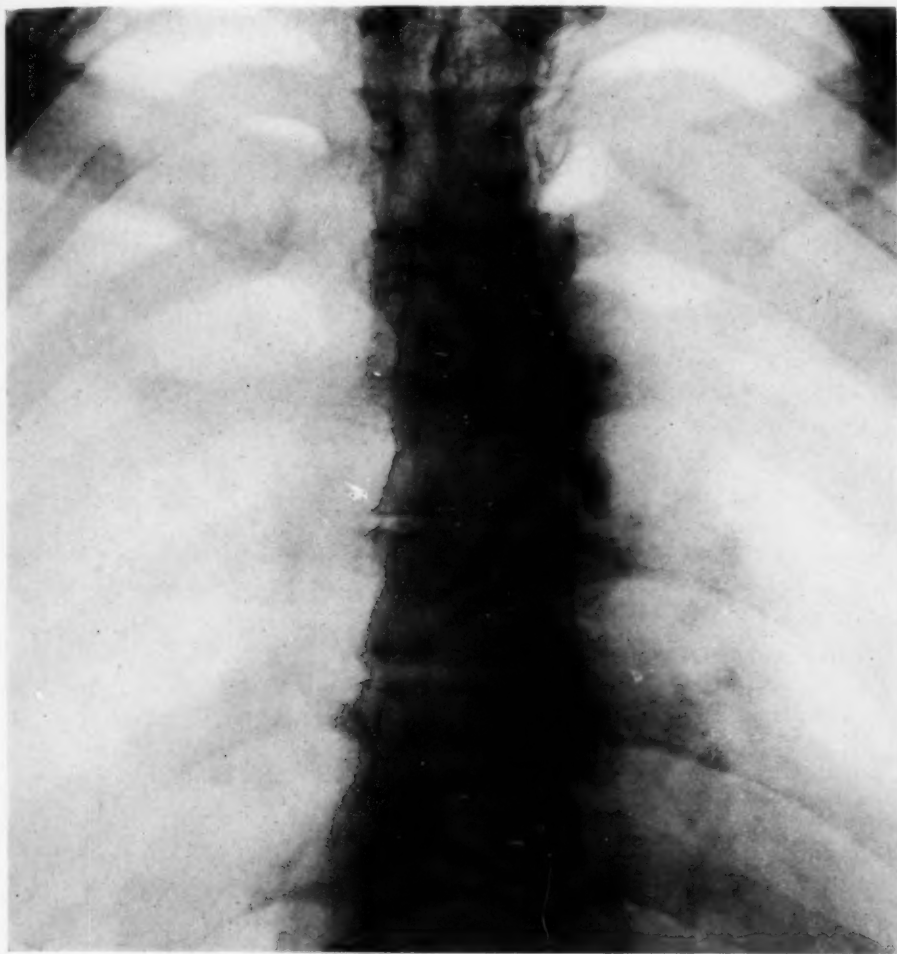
Showing the X-ray appearances in a patient with a spinal cord tumor, who had Pott's disease many years before at the same level as the tumor.
